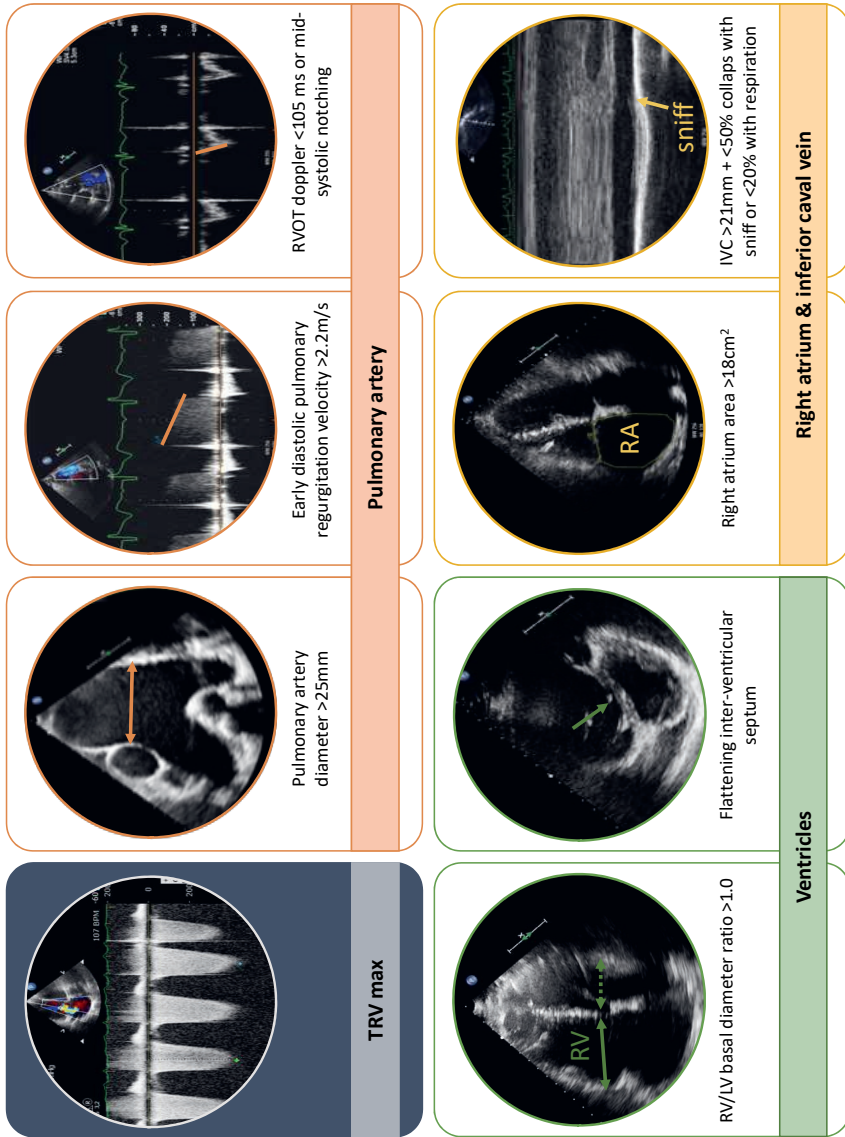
Echocardiographic signs of pulmonary hypertension.
